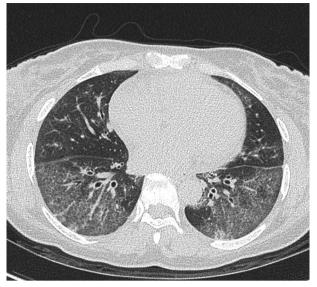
Computed tomography image of the lung showing fibrotic non-specific interstitial pneumonia changes caused by underlying connective tissue disease.
